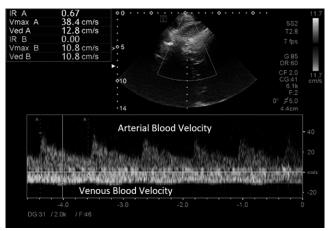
An example of the middle cerebral vein assessment using transcranial Doppler. For the measurement of MCVv, the Doppler gate was first positioned to obtain middle cerebral artery velocity (top of Doppler spectrum) and adjusted slightly until the venous velocity (bottom of the Doppler spectrum) was clearly visible for assessment.
